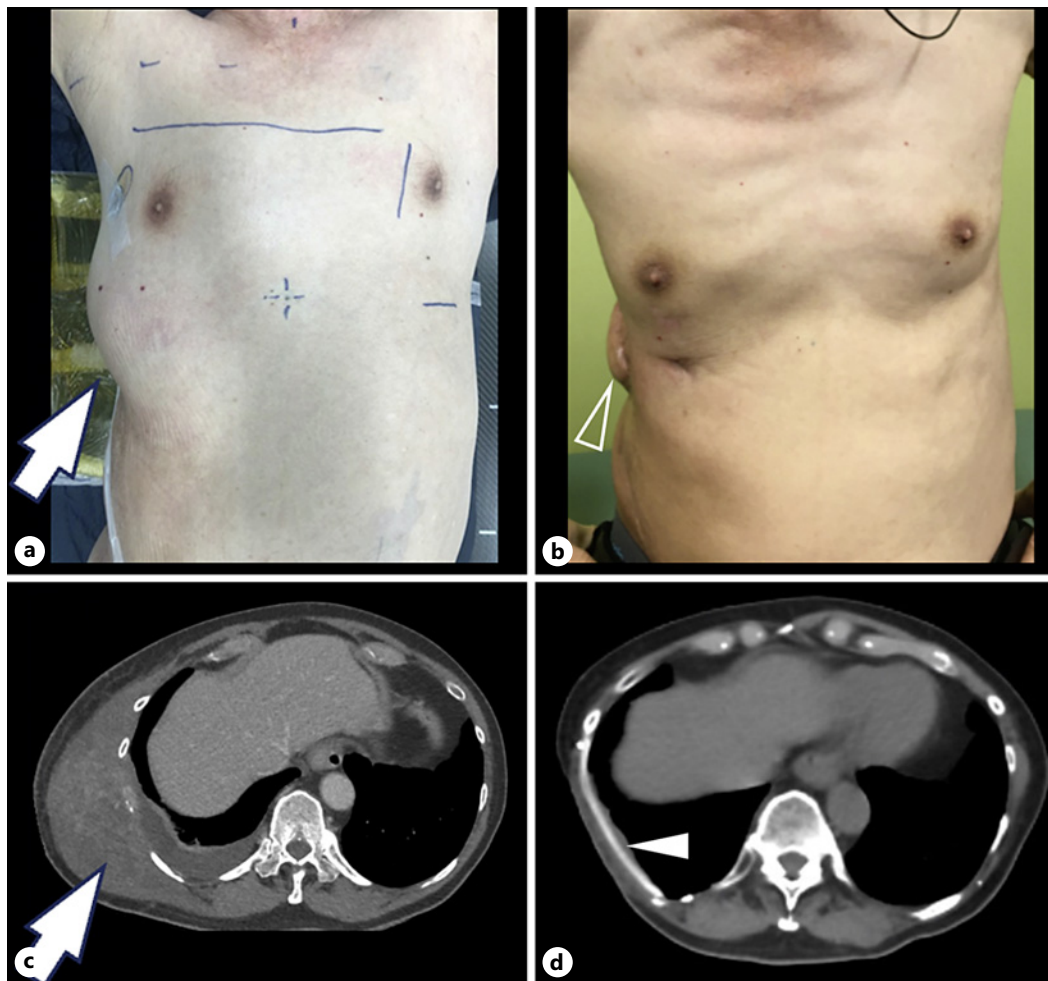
a, b Tumor recurrence before re-irradiation. a Clinical photograph showing the recurrent liposarcoma in the right lateral chest wall (arrow). Radiotherapy set-up skin markers are seen on the patient's chest. b Representative axial CT through the lower thorax demonstrating the tumor recurrence at the right lateral chest wall involving the underlying ribs (arrow). c, d Three months after chemotherapy, re-irradiation, and surgical resection. c Photograph showing the post-therapy appearance with slight bulging of the tissue at the site of surgical flap repair but an otherwise very good cosmetic outcome. d Representative axial CT showing resolution of the recurrent right lateral chest wall mass and note the Gore-Tex chest wall implant forming part of the right lateral thoracic cage reconstructions.
